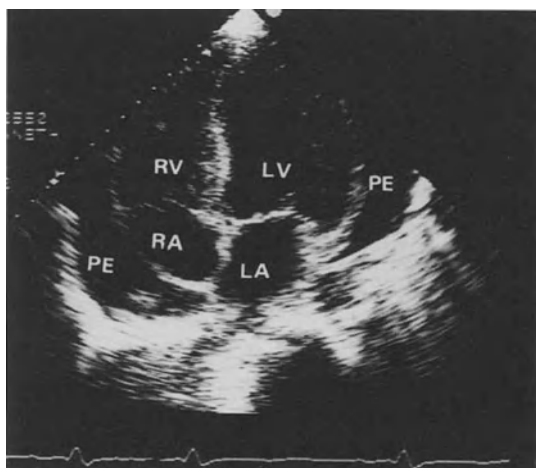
2D Echocardiogram (four chamber view) in pericardial effusion (PE).
